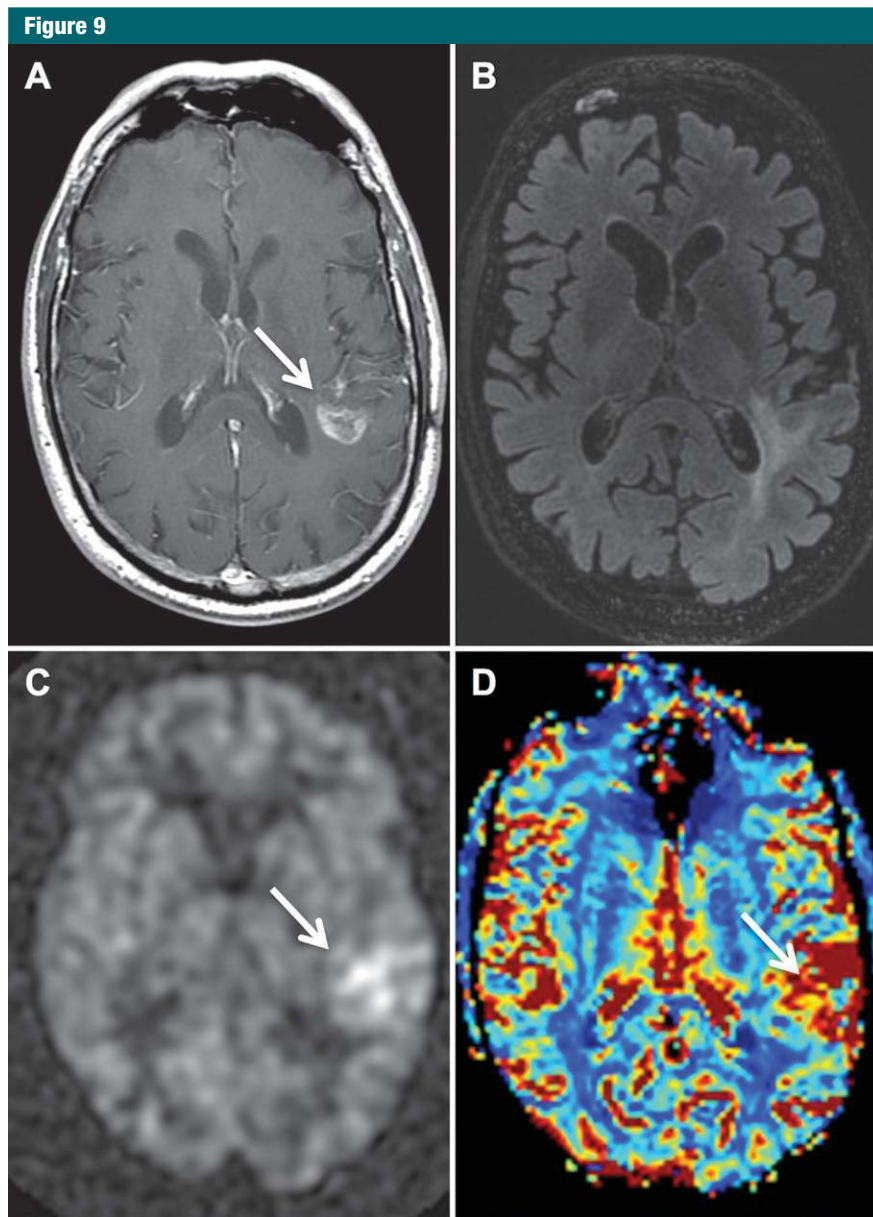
Images in 78-year-old man with unresectable anaplastic astrocytoma (arrow) (World Health Organization Grade 3), seen on, *A*, postcontrast T1-weighted and, *B*, FLAIR images. *C*, ASL image demonstrates increased CBF (arrow) in the region of the tumor. *D*, Increased cerebral blood volume (arrow) is also visible on bolus DSC image, though it is more difficult to appreciate due to the extensive number of arterial and venous vessels that surround the tumor. The findings of high CBF are characteristic of high-grade (grades III and IV) glial neoplasms.
